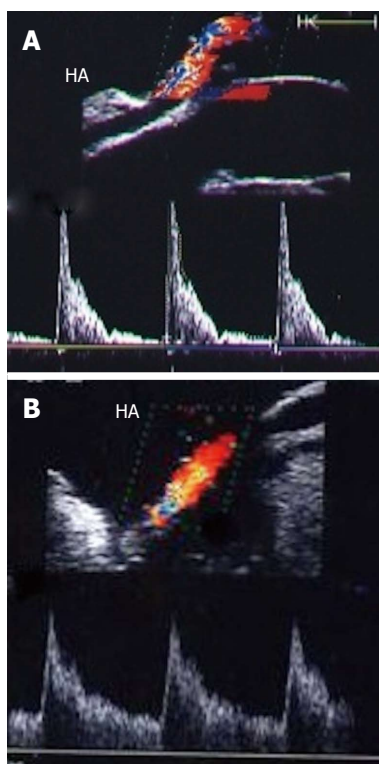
Intra-operative hepatic artery vasospasm. A: Intra-operative Doppler US image showing high resistance flow in the HA with low diastolic flow and normal systolic upstroke; B: Doppler US image of the HA after intra-operative papaverine installation showing relief of spasm, regaining the normal biphasic Doppler waveform, and a continuous diastolic flow throughout the cardiac cycle. HA: Hepatic artery.
